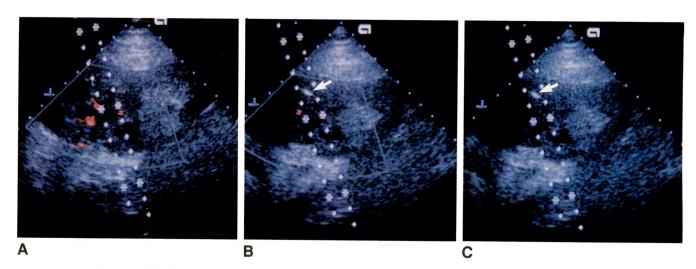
Doppler images of renal-mass biopsy.
